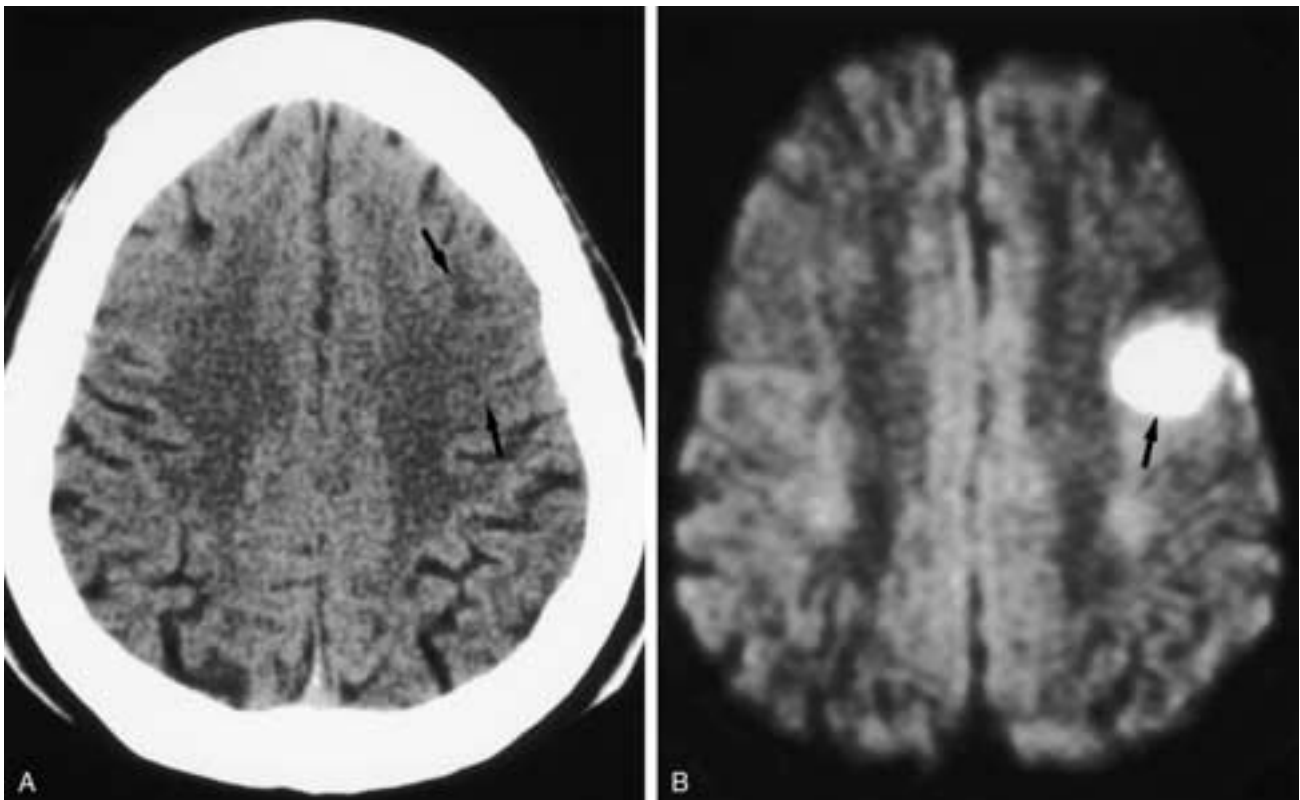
Acute embolic ischemic infarction in a 17-year-old female. A, CT image without contrast shows subtle posterior frontal cortical and subcortical hypodensity (*arrows*). B, Diffusion-weighted image shows acute infarction as high signal intensity (*arrow*).
